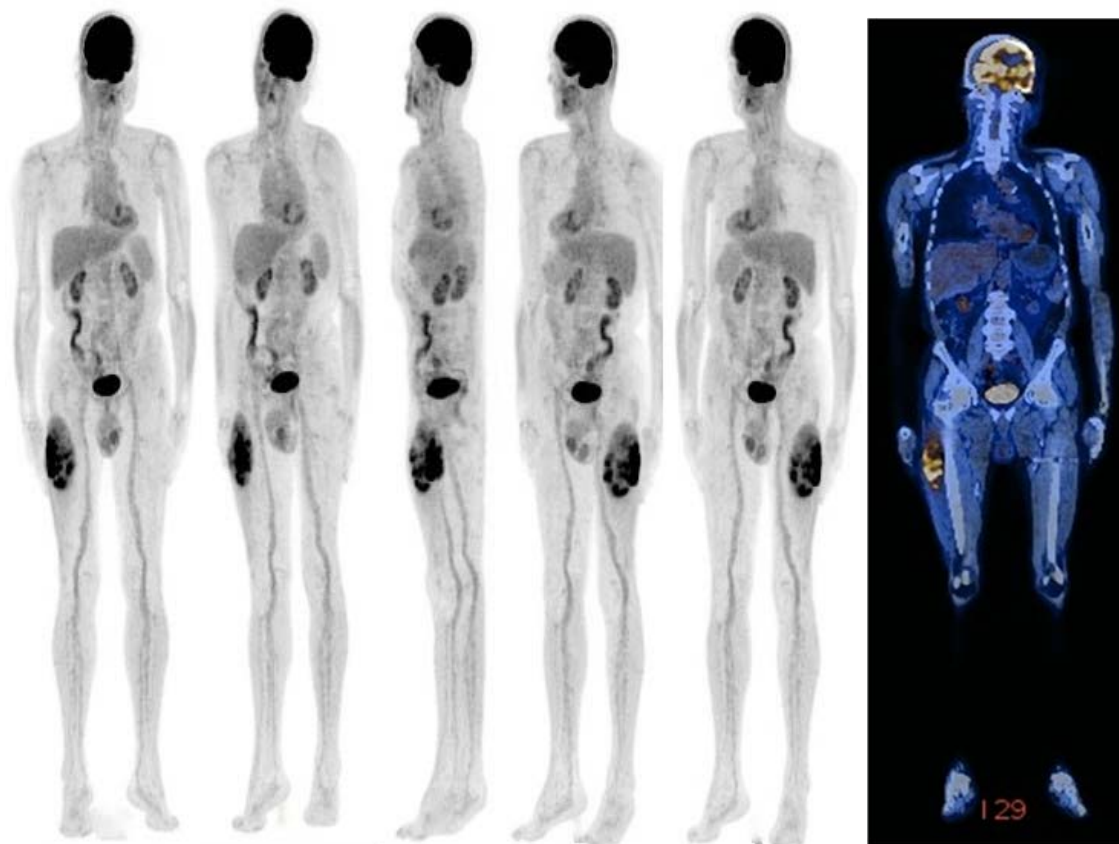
6 PET-CT images (reproduced with the consent of the patient from his personal archive)
